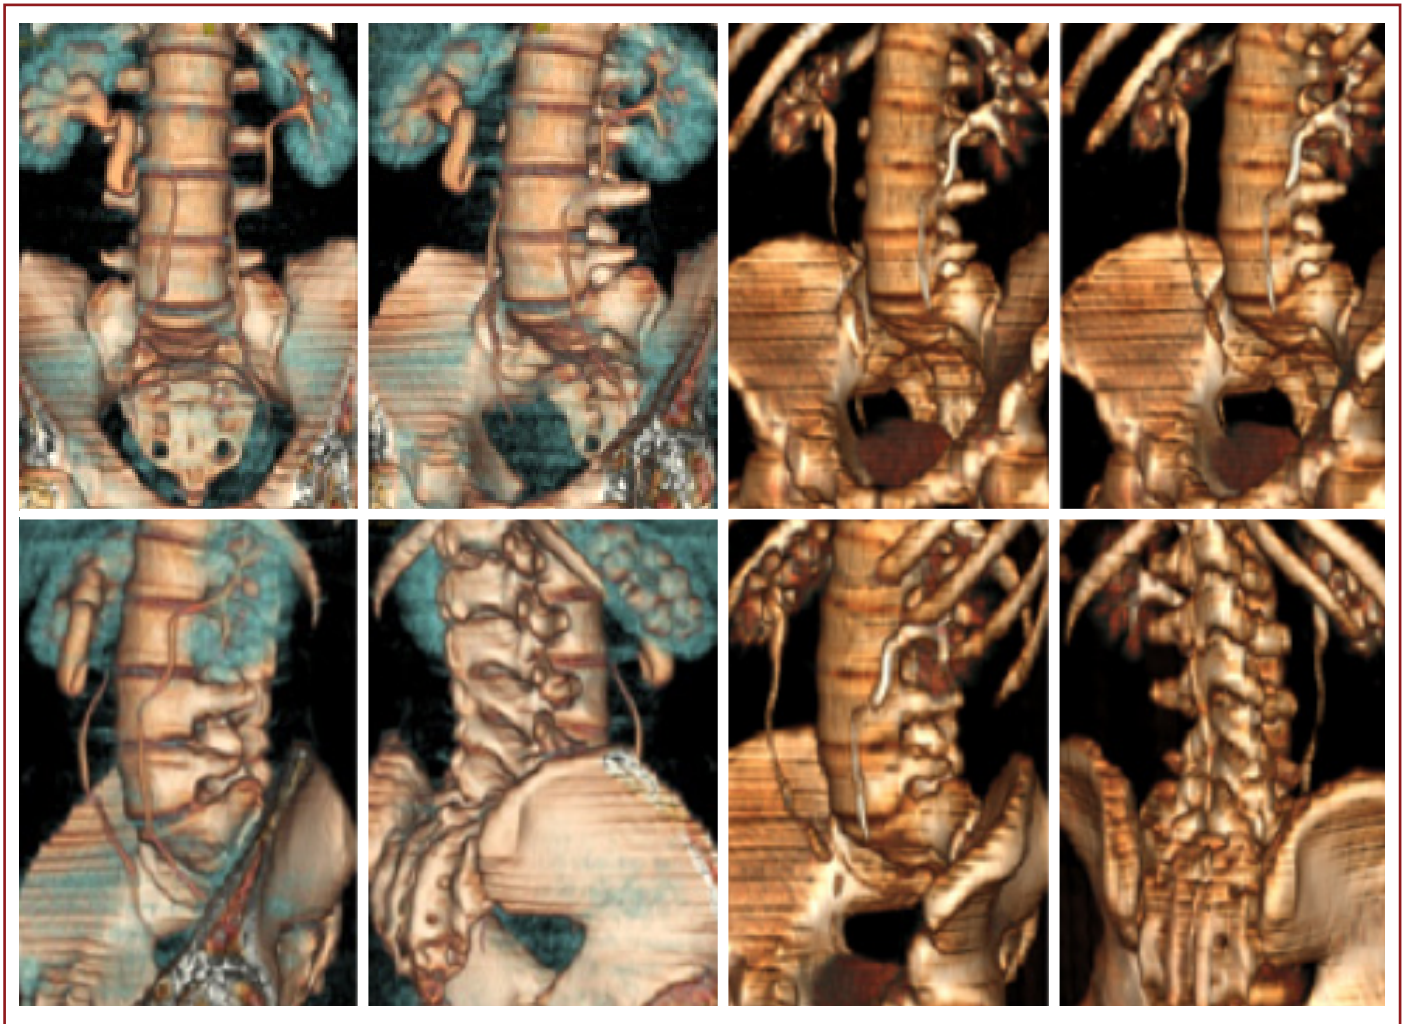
Classical “Shepherd’s crook” appearance on computed tomography, 3D constructed.
